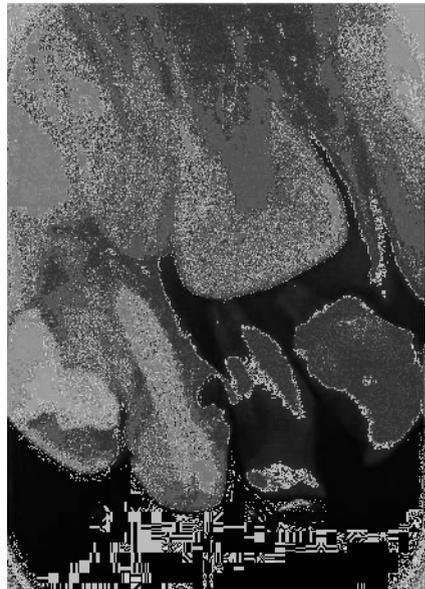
Root canal treatment using Endoflas, performed in a primary right second mandibular molar. Figures (a, b) are pre- and postoperative radiographs. Radiograph (c) demonstrates enlargement of the dental sac of the mandibular right second premolar 3 months later
